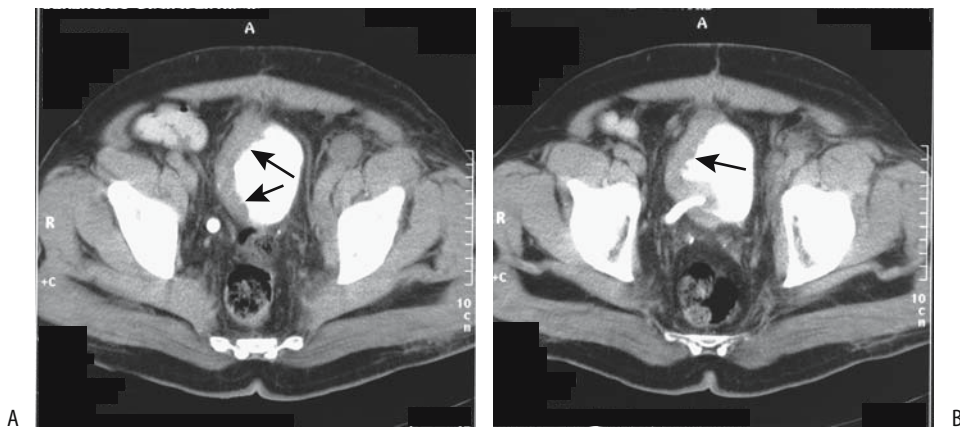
Invasive bladder carcinoma. More superior (A) and inferior (B) transverse pelvic CT images show marked right-sided bladder wall thickening (arrows). Reflux into the right ureter is evident. The cancer is extending almost to the anterior abdominal wall. (Courtesy of Egle Jonaitiene, M.D., Kaunas Medical University, Kaunas, Lithuania.)
